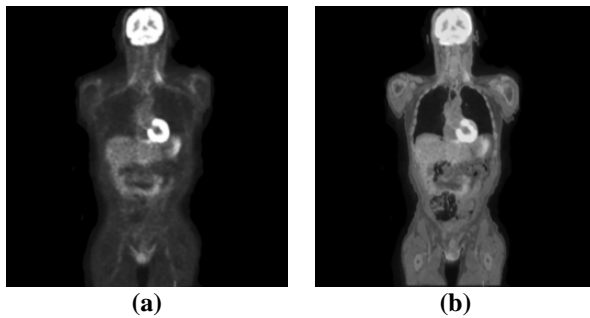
(a) Transformed PET image,(b) PET-CT fusion
